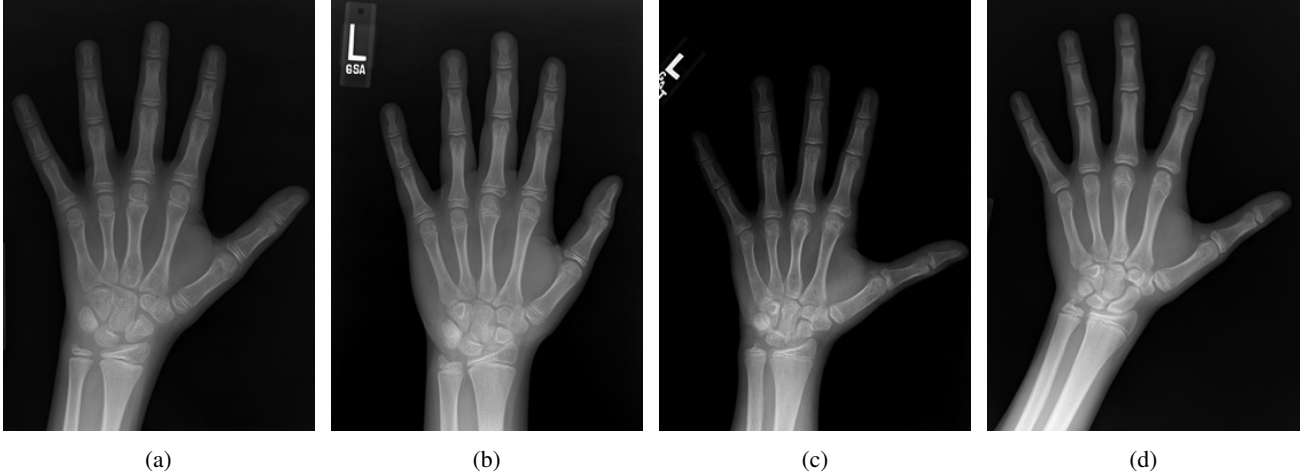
Radiographs of male patients with bone age values of (a) 12 years, (b) 13 years, (c) 14 years and (d) 15 years. G&P’s method requires visual comparison of these images with the normalized examples contained in the atlas.
